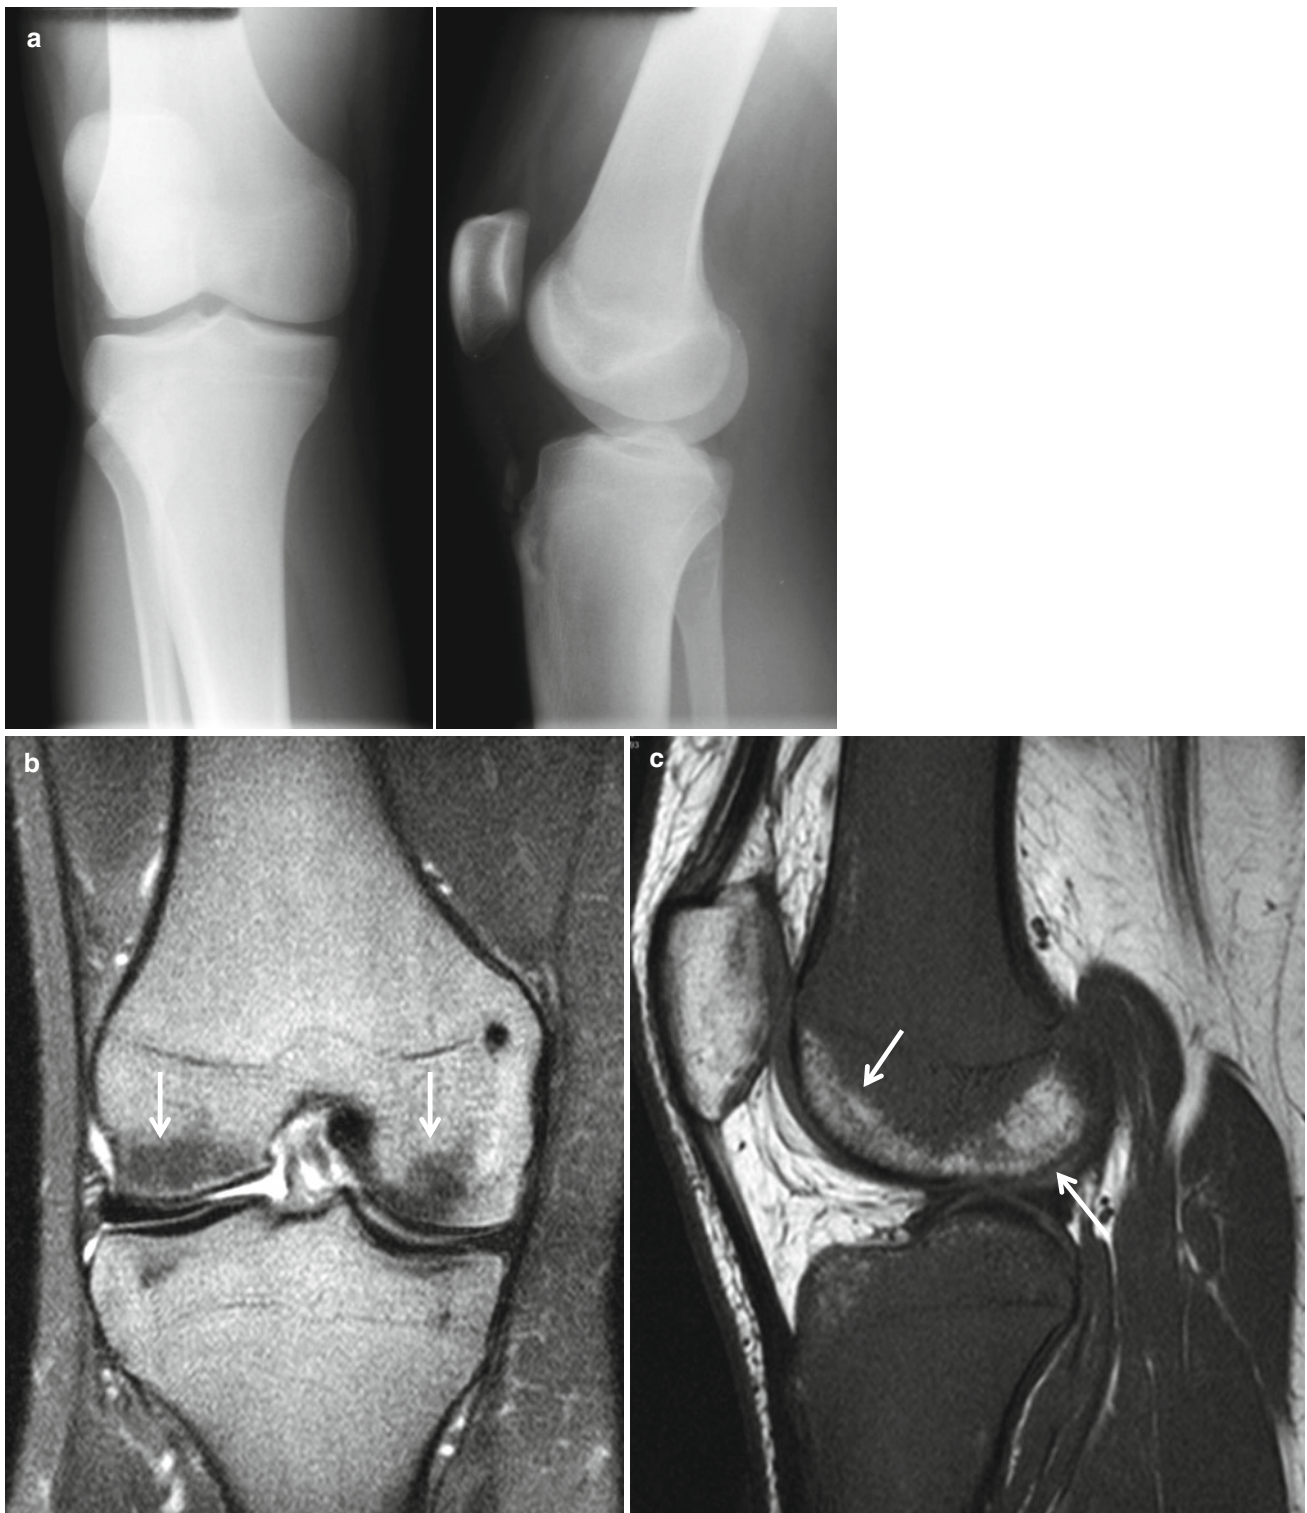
A 17-year-old boy presented with left knee pain from chronic myeloid leukemia. (a) Plain radiographs of the knee demonstrate no bony abnormalities. (b, c) Coronal T2-WI with fat suppression (b) and sagittal intermediate signal intensity images (c) demonstrate
